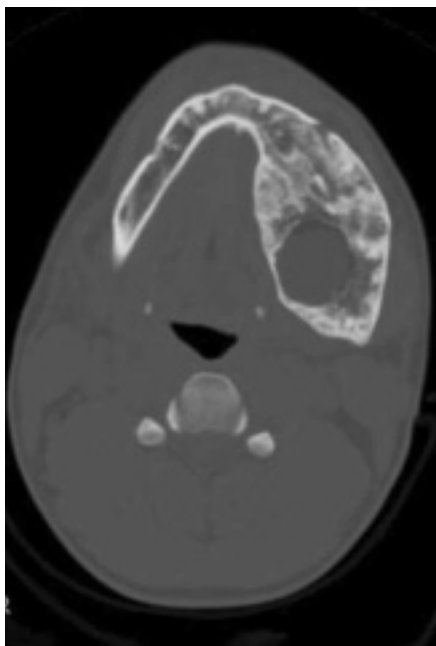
Axial computed tomography view of the mandible (bone window setting). The centre of the lesion is radiolucent.
